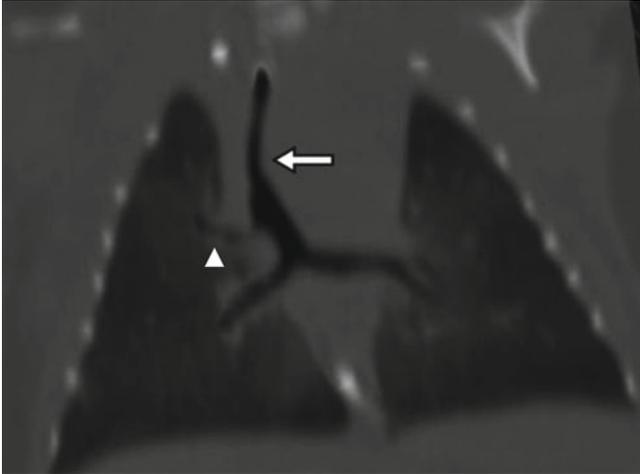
Tracheal stenosis and accessory tracheal bronchus. Reconstructed coronal CT image shows a long segment area of tracheal narrowing (*arrow*) and an accessory right bronchus (*arrow-head*) arising from the trachea
